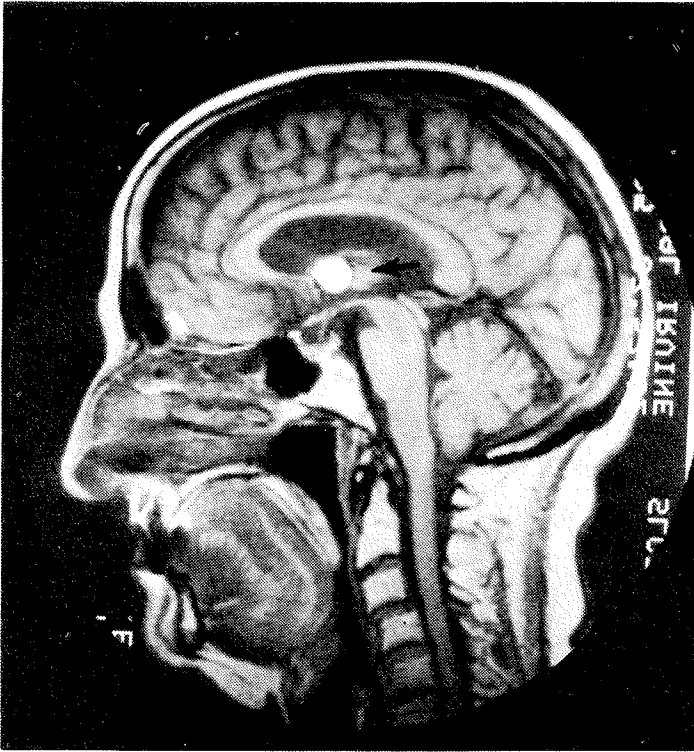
Colloid cyst of third ventricle. Sagittal MR image shows cyst as a high intensity (white) lesion due to the protein content.
